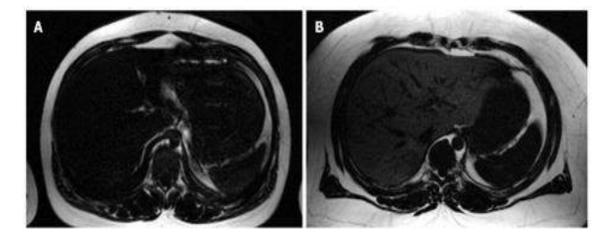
Abdominal fat-only MRI images. The Dixon-MRI sequences enable visual comparison between low and high fat deposits, for example in lean (A) and obese subject (B) respectively (Springer et al., 2010).
